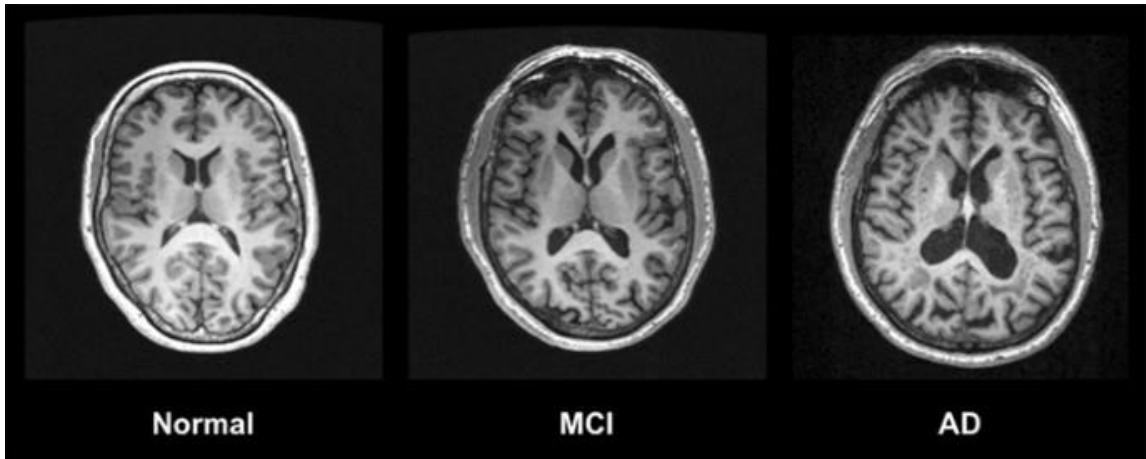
Changes in the brain of normal, MCI, and AD individuals, captured via MRI.
